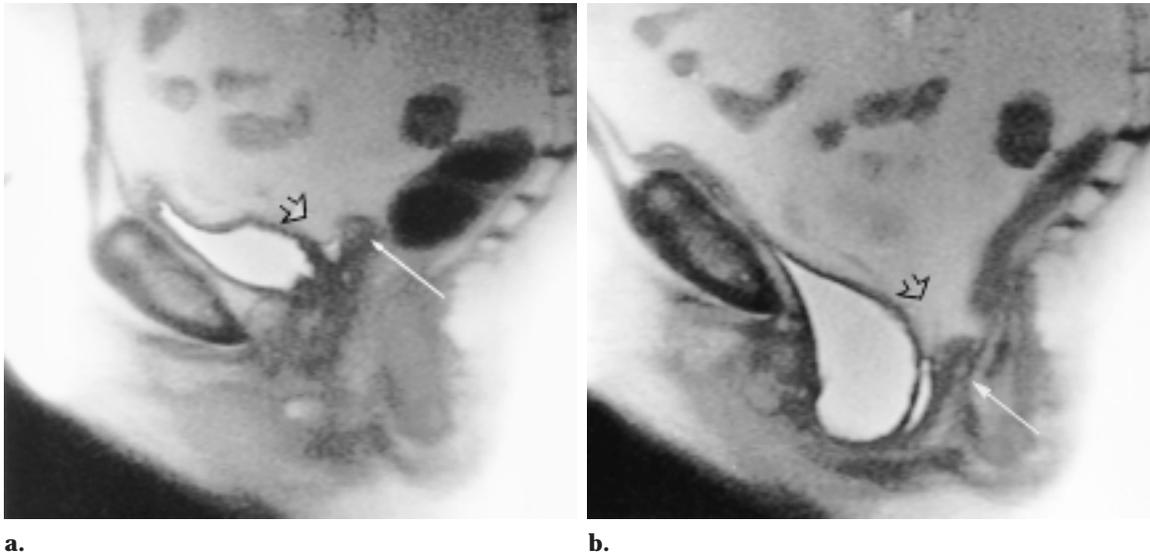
Vaginal vault prolapse in a 52-year-old woman with pelvic pain and pressure. Sagittal T2-weighted MR images of the pelvis obtained with the patient at rest (a) and straining (b) demonstrate inferior prolapse of the vaginal vault during straining (solid arrow). As a result, the cul-de-sac (open arrow) also descends. There is peritoneal fat in the cul-de-sac, but bowel may be present. Bladder descent also occurs with straining.
